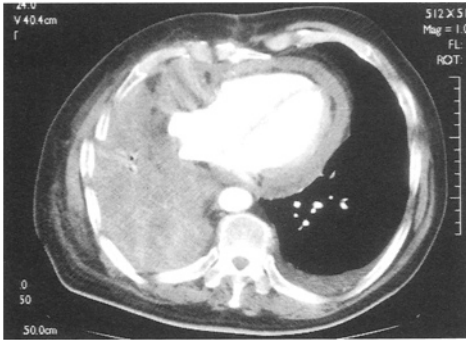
CT scan: 65 year old man with a biphasic mesothelioma. There is an extensive bulky tumour mass within the right hemithorax which is slightly contracted. The tumour has invaded the pericardium which shows diffuse thickening. There is a small left pleural effusion
